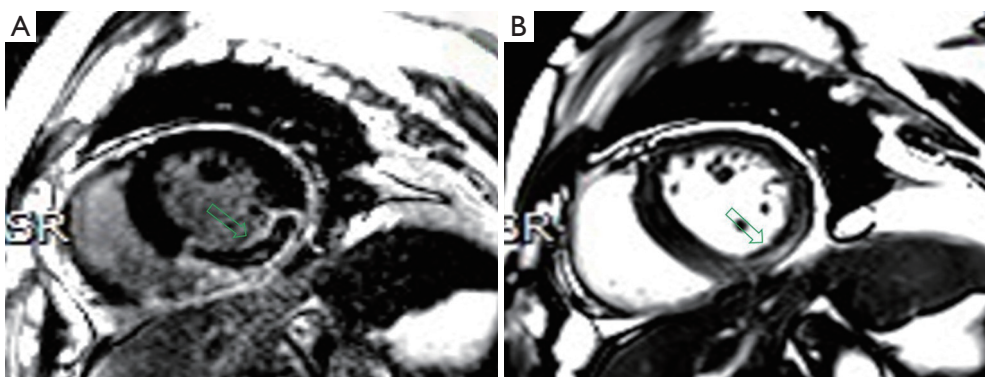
A 61-year-old woman with STEMI. (A) Short axial LGE-MR image shows the region of delayed enhancement with banded low signal (arrow) at the inferior wall of the left ventricle, which is interpreted as MI with MVO. (B) Short axial cine CMR image at corresponding slice of (A) shows heterogeneous intensity at the inferior wall of the left ventricle (arrow). The 5 radiomic measurements (shape maximum 2D diameter slice, first order mean, GLSZM gray level non-uniformity, Gldm large dependence high gray level emphasis, and Ngtdm strength) are 0.45, 0.86, 0.89, 0.58, -0.43, respectively. The radiomic score is 0.54. STEMI, ST-segment elevation myocardial infarction; LGE-MR, late gadolinium enhancement-magnetic resonance; MI, myocardial infarction; MVO, microvascular obstruction; CMR, cardiac magnetic resonance.
